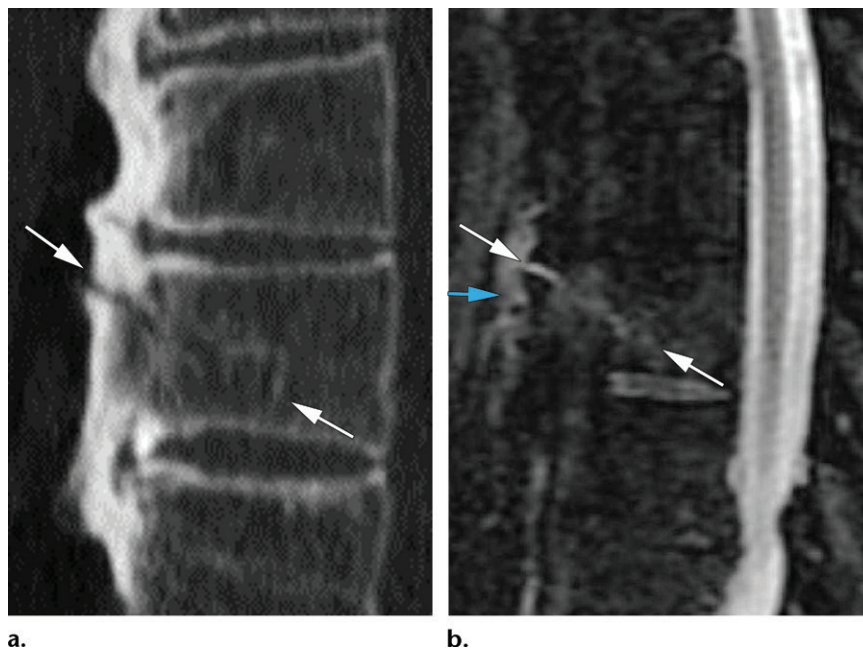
ALL injury in a 55-year-old man with DISH who slipped in the bathtub and presented with back pain. No neurologic deficit was diagnosed. (a) Sagittal CT image shows a transverse midvertebral body fracture (arrows) at T8 that does not extend through the posterior vertebral cortex or posterior elements. MRI was performed to assess for ligamentous injury. (b) Sagittal short τ inversion-recovery (STIR) MR image shows the fracture (white arrows) and edema around the ALL (blue arrow), but there is no injury to the posterior longitudinal ligament or spinal cord. The injury was conservatively managed.
